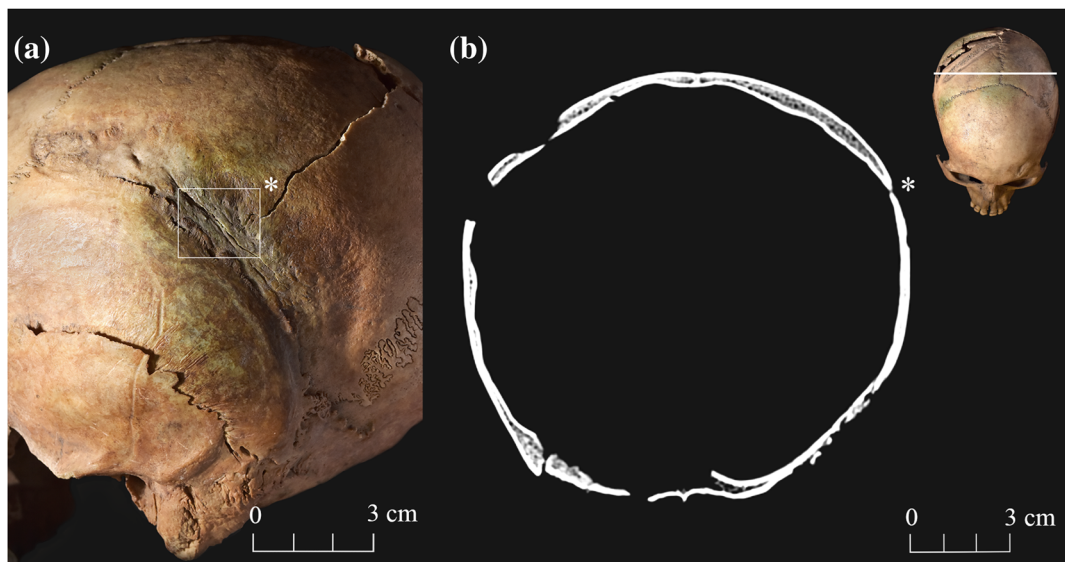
Lesion #2. (a) Postero-lateral view of the cranium. Elongated lesion of the left parietal bone and on the occipital bone with a deficient area in square. (b) Computed tomography in the coronal plane (upper right corner) from the deficient area [Colour figure can be viewed at wileyonlinelibrary.com]
